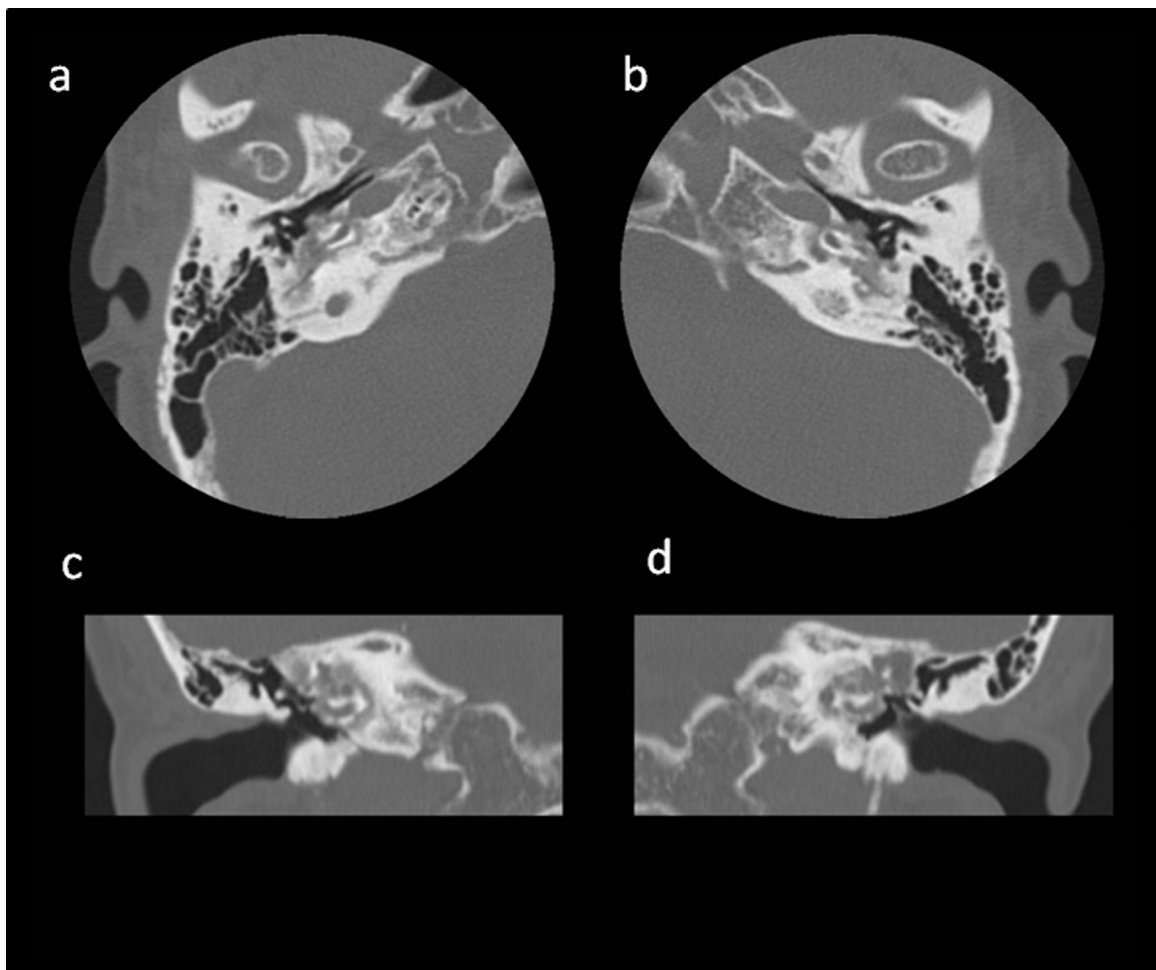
Preoperative CT image of the cochlea. High resolution computed tomography (HRCT) revealed significant demineralization of the right and left pericochlear and vestibular areas, and the structures of the cochleae were almost unrecognizable.
